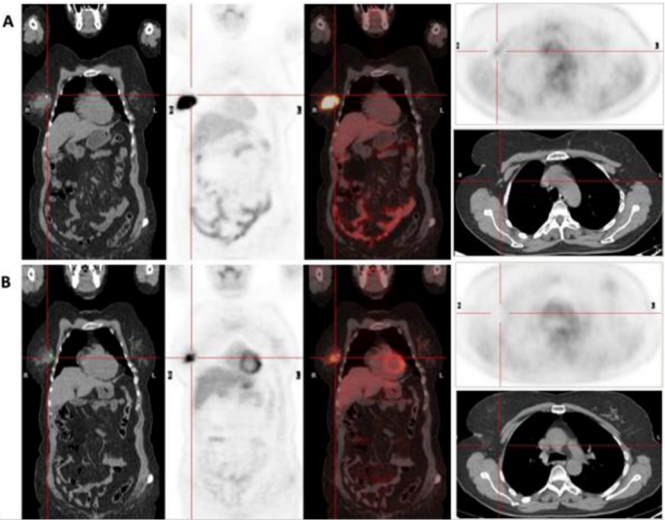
Female with right luminal B HER-2 (-) breast cancer with lymph node involvement. (a) Coronal and axial slices of baseline 18F-FDG PET/CT showing a significant increase of metabolism in the breast lesion and a mild increase in the axillary lymph node. (b) Coronal and axial slices of post-treatment PET/CT showing reduced metabolism and size of the mammary lesion, with no pathologic metabolism in the axillary lymph node. Surgery revealed a partial response in the breast lesion and a complete response in the lymph node. PET/CT correctly classified both responses.
